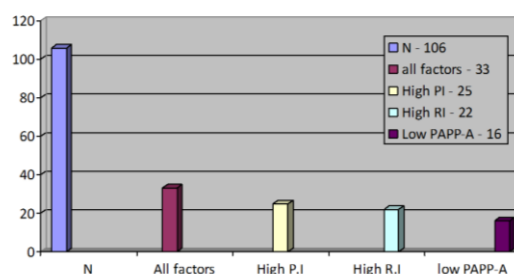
The combination of the low PAPP-A values and the abnormal Doppler test of the uterine arteries
